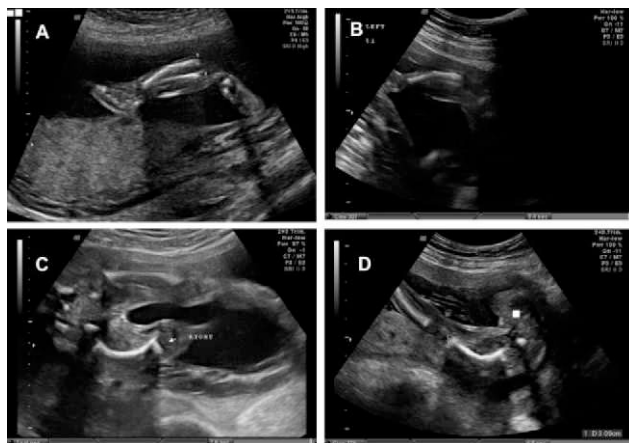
Prenatal ultrasound showing mildly curved lower limbs.
